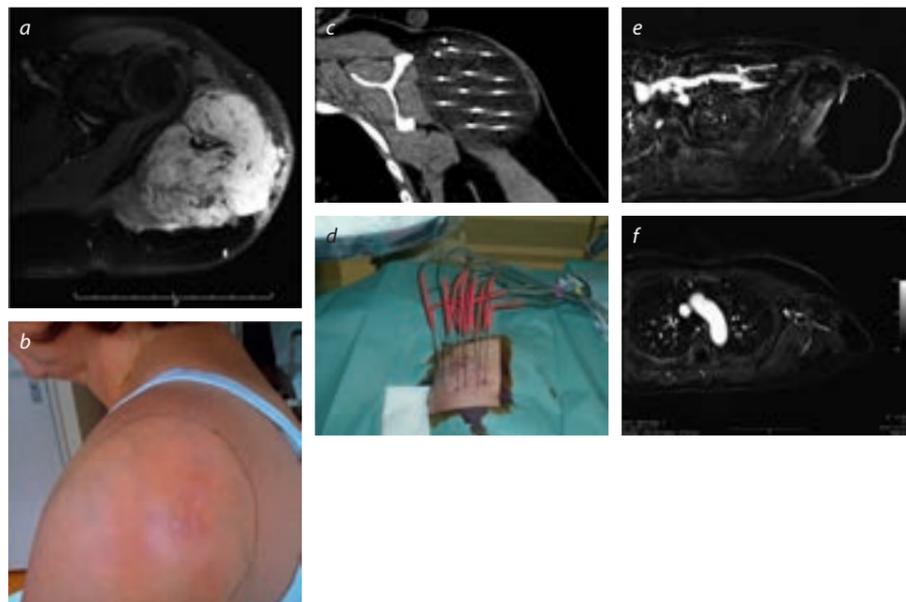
(a, b) Voluminous local recurrence after surgical resection of an extra-abdominal DT on the left shoulder. (c, d) Fourteen cryoprobes were placed under CT-guidance for ablation of the tumour. Note the hypodense ice ball covering the majority of the lesion. The patient had a small residual lesion that was also treated with percutaneous cryoablation under MR guidance. (e, f) The MR at 3 months and 1 year post-treatment revealed complete necrosis of the lesion and significant volume reduction.
